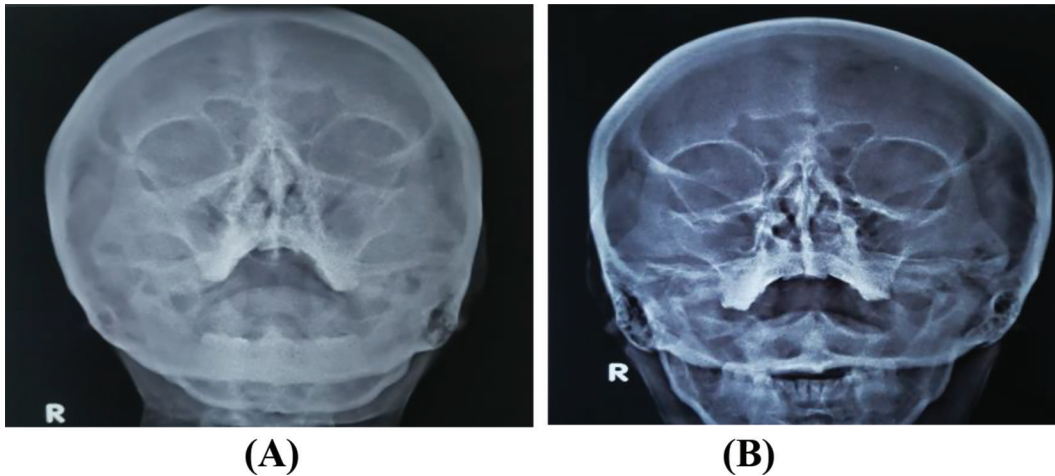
X-ray PNS Waters view before (A) and after (B) treatment.
